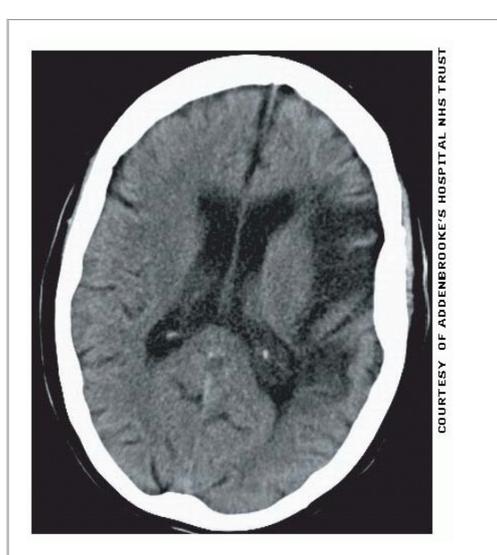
Unenhanced axial CT head: note the old stroke in the left middle cerebral artery territory.
